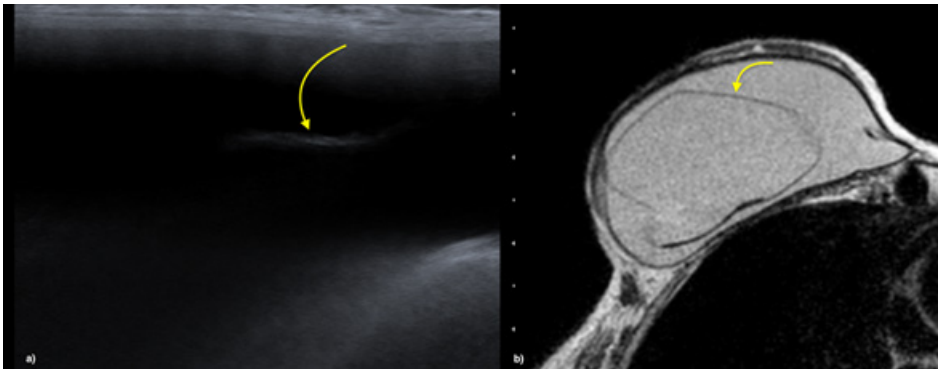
An 85-year-old woman with a history of bilateral mastectomy for bilateral breast carcinoma and reconstruction with implants 20 years ago. In the ultrasound study (a) the loss of the usual trilaminar contour was verified, identifying the presence of the “subcapsular line” signal (arrow). The MRI study was consistent (b), revealing detachment of the internal membrane of the implant, being compatible with intracapsular rupture. This should not be mistaken with the presence of periprosthetic fluid, reason why it is crucial to evaluate the trilaminar line.
